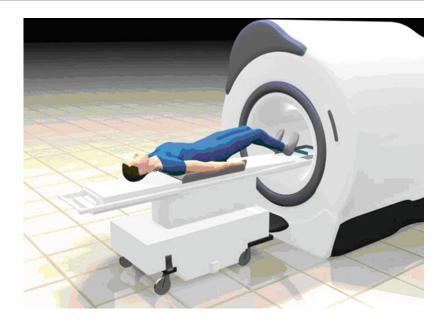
Integrated MR imaging and focused ultrasound therapy unit (With permission from Insightec Ltd)
